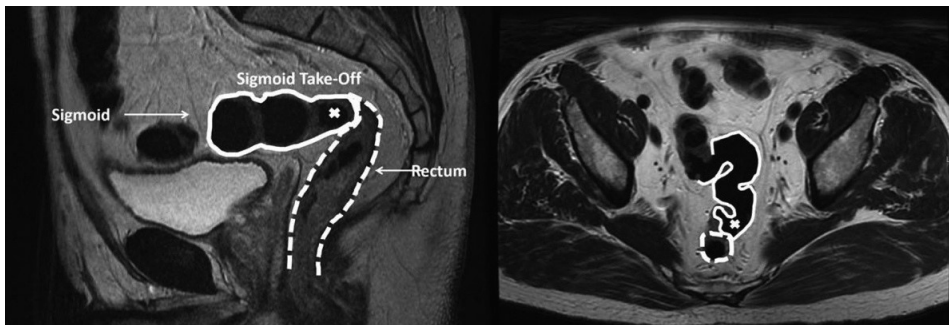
Sagittal (left) and transversal (right) pelvic MRI of a male displaying the sigmoid take-off (cross), the distinction between the sigmoid (solid outline) and the rectum (dashed outline). At the sigmoid take-off, the sigmoid sweeps away ventrally from the sacrum [12]
